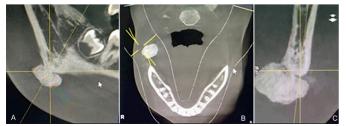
Cone beam computed tomography (CBCT) images (A) Coronal (B) Axial (C) Sagittal view showing a dense bony lesion on the angle of rightmandible.
